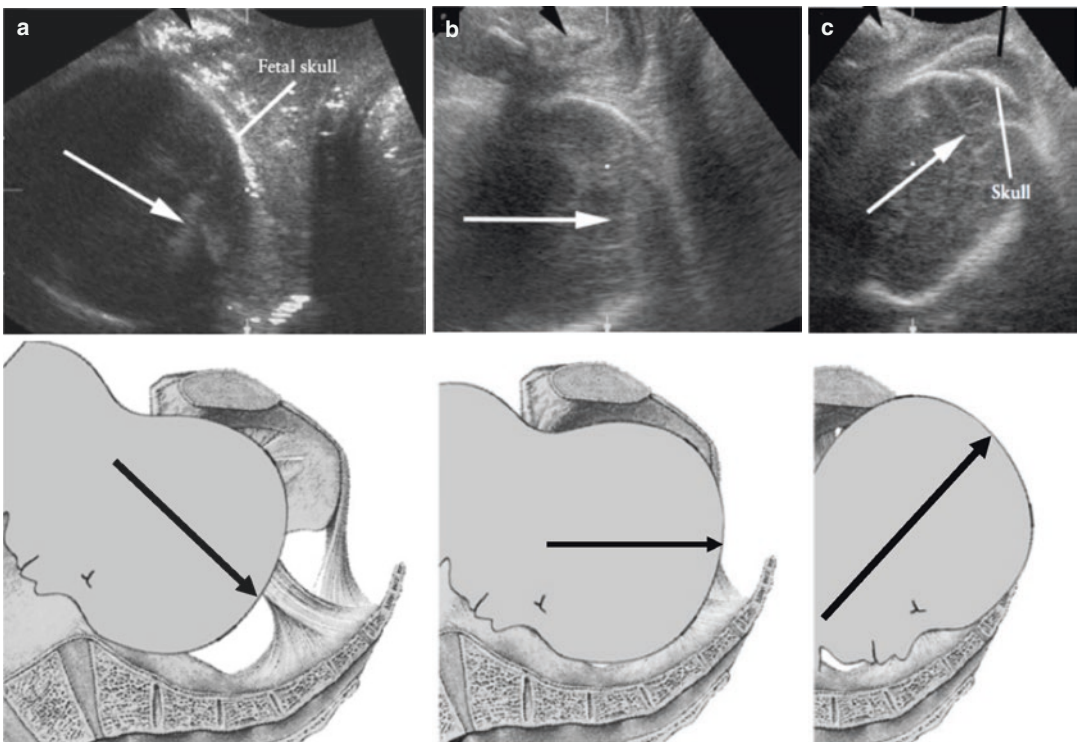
Categorization of fetal head direction (indicated by black arrows) in longitudinal translabial sonograms compared: (a) downward direction; (b) horizontal direction; (c) upward direction [23]
